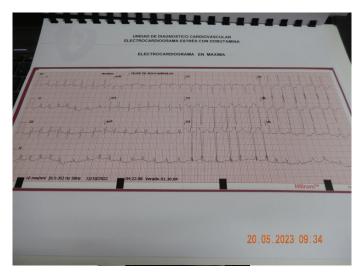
The diagnoses regarding cardiac alterations were as follows: 1) Left ventricle with severe concentric hypertrophy, preserved systolic function: EF 60%. 2) High left ventricular end diastolic pressure data. 3) Normal valve function, 4) No pulmonary arterial hypertension (PAH), 5) Severe dilation of the left atrium, 6) Right ventricle with mild basal dilation, preserved contractility, 7) No images suggestive of thrombi, 8) Pericardium without alterations, 9) Echocardiogram with Dobutamine negative for myocardial ischemia, with 114 % of its MHR.
